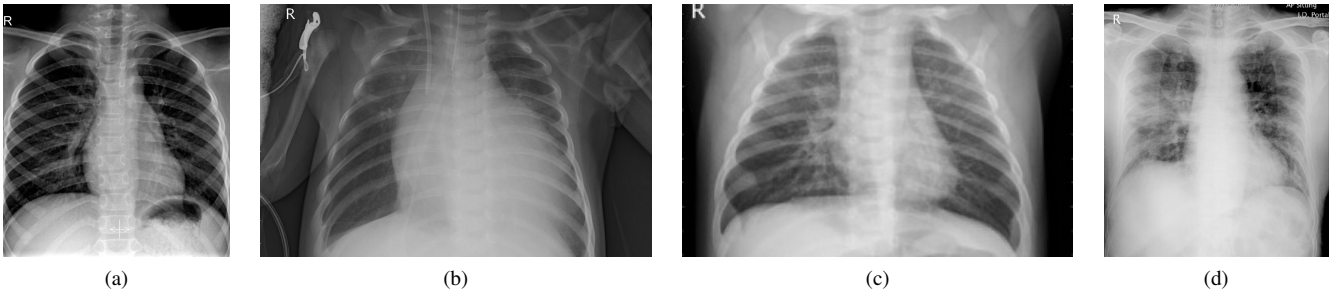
Chest-x-ray samples showing a healthy patient (a), pneumonia from a bacteria infection (b), pneumonia from a virus infection (c), and pneumonia from a COVID-19 case (d).
